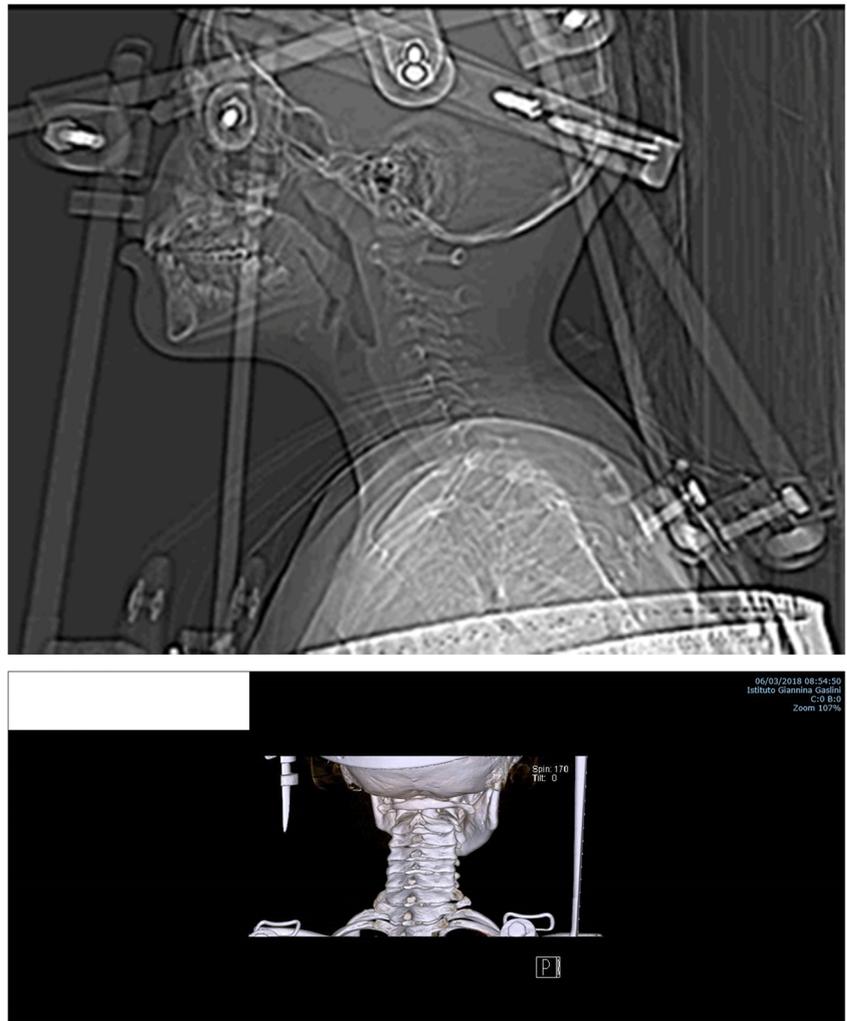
a CT scan ax showing subluxation of the C1-C2 cervical tract. b CT scan 3D showing subluxation of the C1-C2 cervical tract
